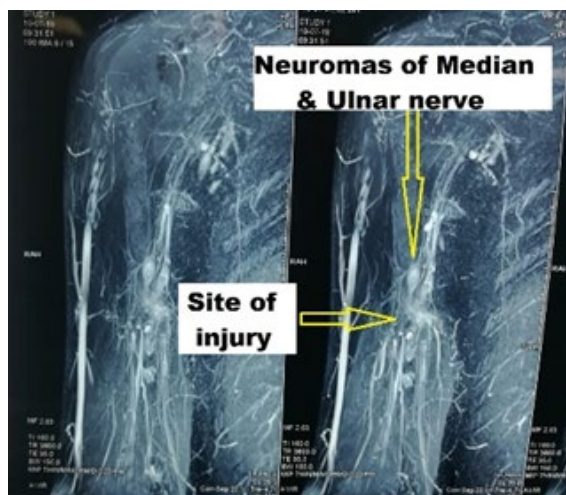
MRI of arm showing the injury site the ends of the injured nerves with neuromas
